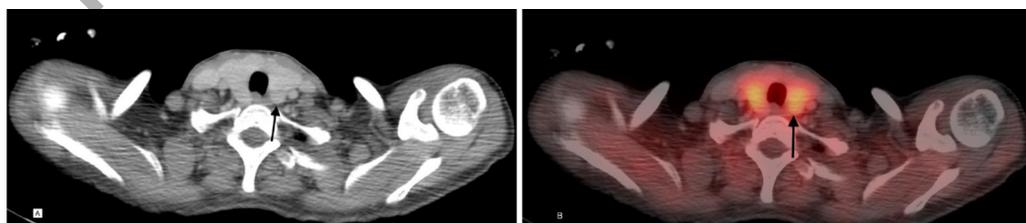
58-year old female patient PTH:767 Ca:13,2 localization of adenoma on contrast-enhanced MIBI SPECT/CT A) Parathyroid adenoma 11mm in size in the thyroid gland left lobe lower pole on CT (marked with black arrow, B) parathyroid adenoma in the left lobe lower pole (marked with black arrow) on fusion images.
